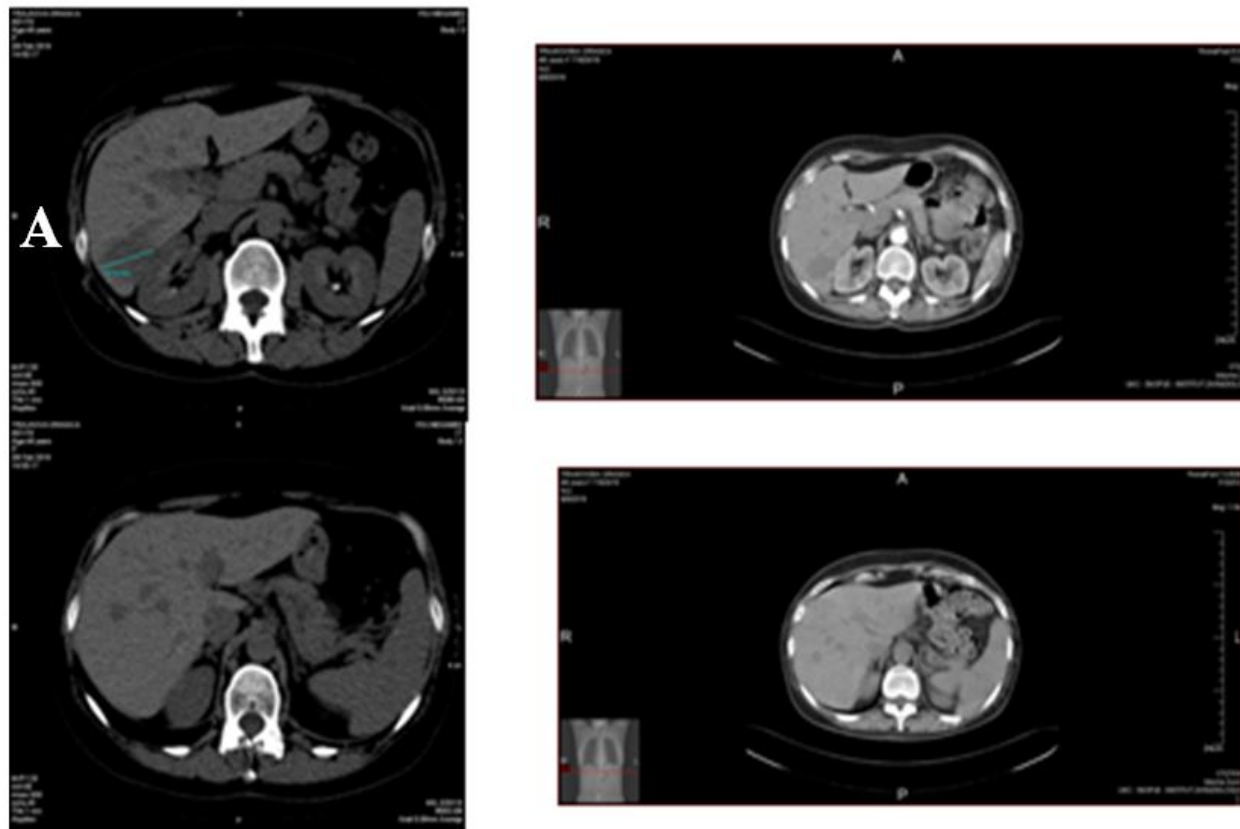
Computed tomography scans depicting the tumor response at the liver, 9 months after alectinib treatment (A pretreatment liver metastatic foci, B positive response to the alectinib after 9 months)
